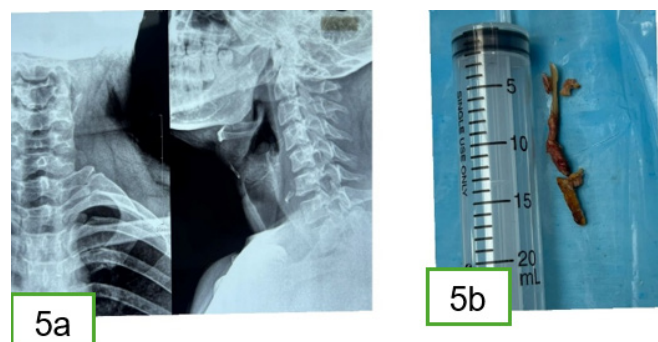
(a) showing the preop Xray of the throat showing the chicken bone. (b) 7.5cm long chicken bone piece removed.
